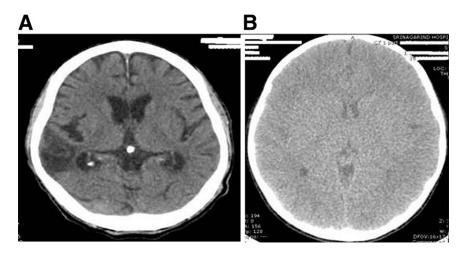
Pineal calcification identified by a computed tomographic scan of the brain in a patient with cerebral infarction (A) compared to a patient without pineal calcification (B).*
